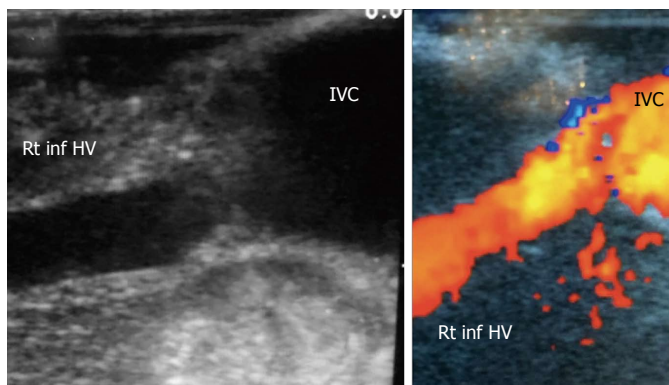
Intra-operative ultrasound evaluation of right inferior hepatic vein anastomosis. B-mode and color US image showing the anastomosis of accessory right inferior HV, end-to-side with the IVC. Rt inf HV: Right inferior hepatic vein; IVC: Inferior vena cava.
